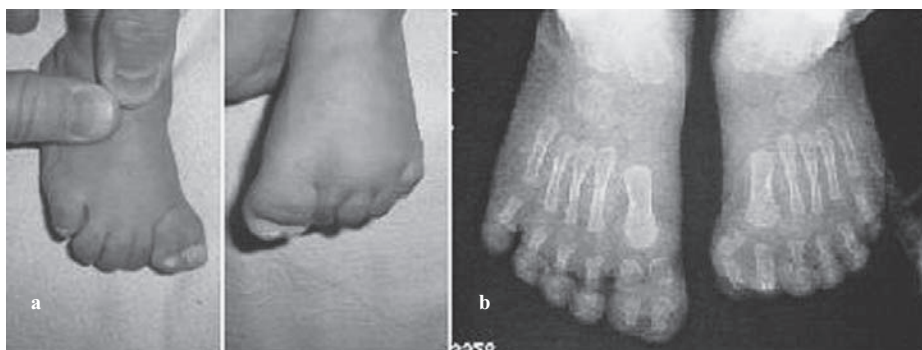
a) Feet of the patient showing bilateral duplicated hallux b) Radiographs of the feet: Bilateral duplication of hallucal phalanges
